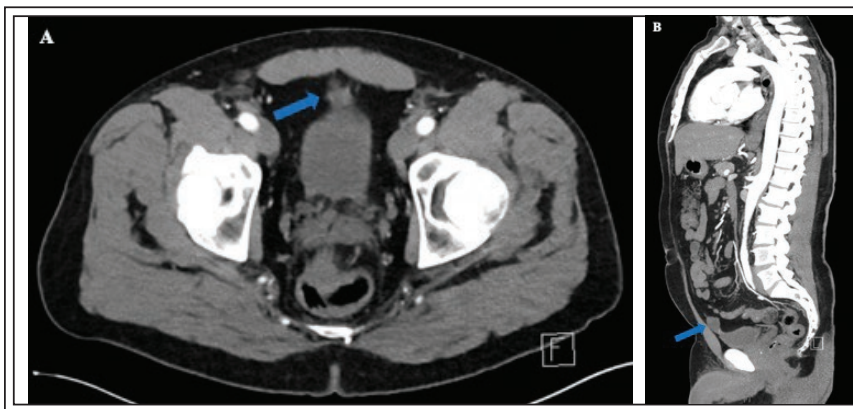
CT of the chest, abdomen and pelvis with intravenous contrast demonstrating the urachal lesion at the anterosuperior aspect of the bladder (arrow). A. Axial view. B. Coronal view.
